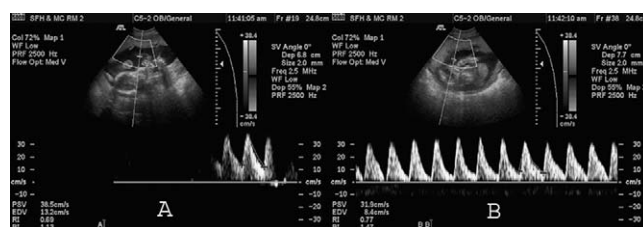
Pulse-wave Doppler of the umbilical arteries in a monoamniotic twin pregnancy.
